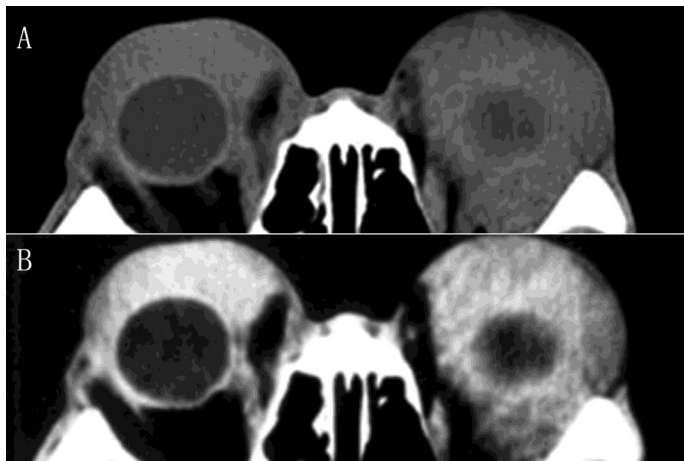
(A-B): The CT films of bilateral diffuse lymphomas. The diffuse, slightly hypodense, soft-tissue lesions are shown bilaterally in the upper quadrant of the orbit (A). The lesions surround the eyeball walls "ring sign". The lesions display homogeneously marked enhancement on computed tomography examination with intravenous contrast (B).
